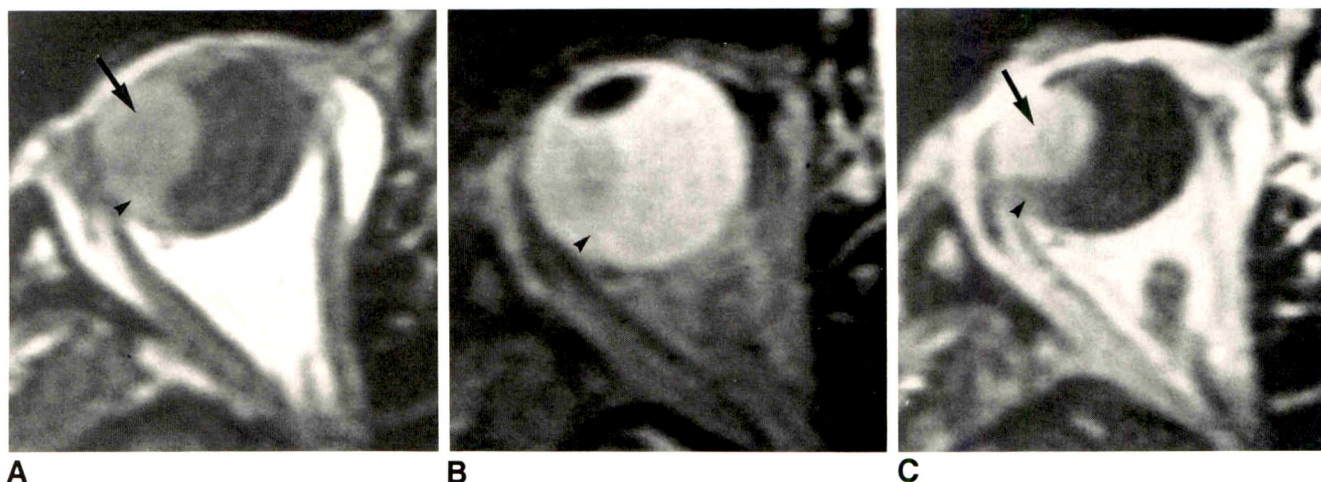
A, Axial noncontrast T1-weighted spin-echo MR image. Choroidal melanoma (arrow) and subretinal fluid collection (arrowhead) could not be clearly separated.
